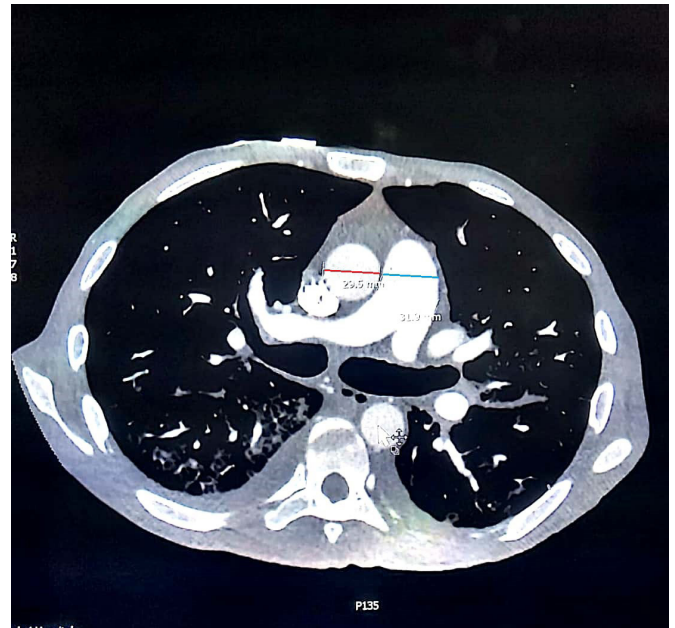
CT pulmonary angiogram showing the transverse diameter of the main pulmonary artery at its bifurcation measures 31.9 mm (blue line) and the ascending aorta measures 29.5 mm (red line).
